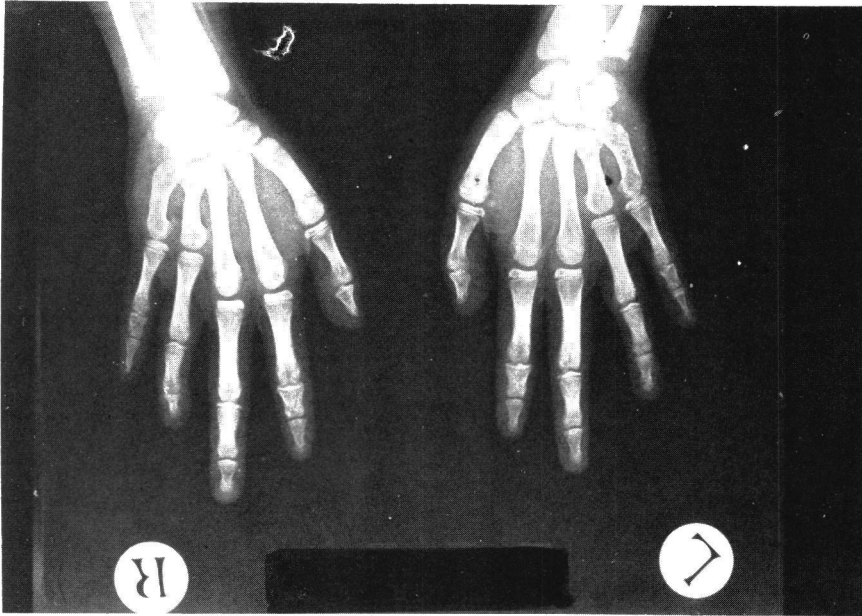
Radiograph Showing Short 4th and 5th Metacarpals of Both Hands.
